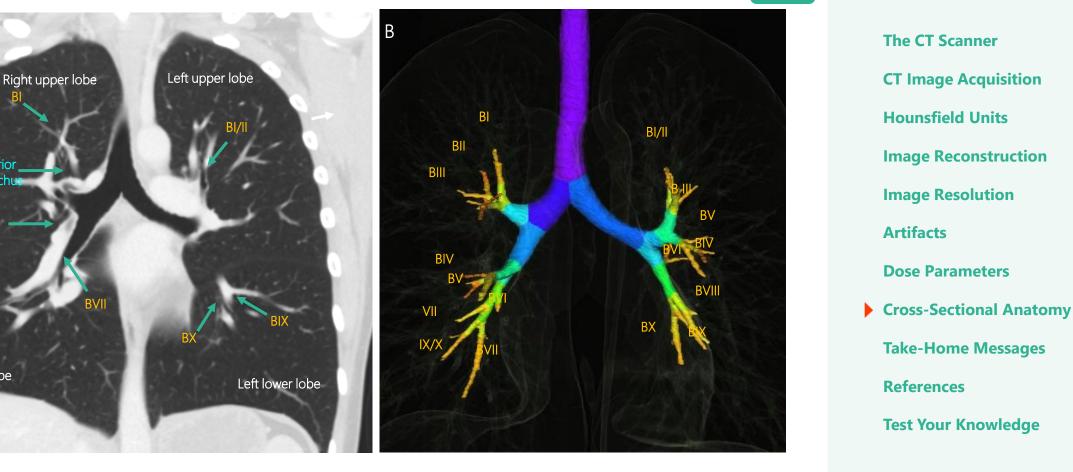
Cross sectional anatomy of the respiratory system. Using the lung window in a CT-Thorax scan, the lung tissue (A) and the bronchial tree (B) can be evaluated. The acquisition and reconstruction of very thin slices allows an accurate assessment of the segmental bronchi with respect to intraluminar pathologies. In figure A some segments of the bronchial tree are annotated exemplarily.
